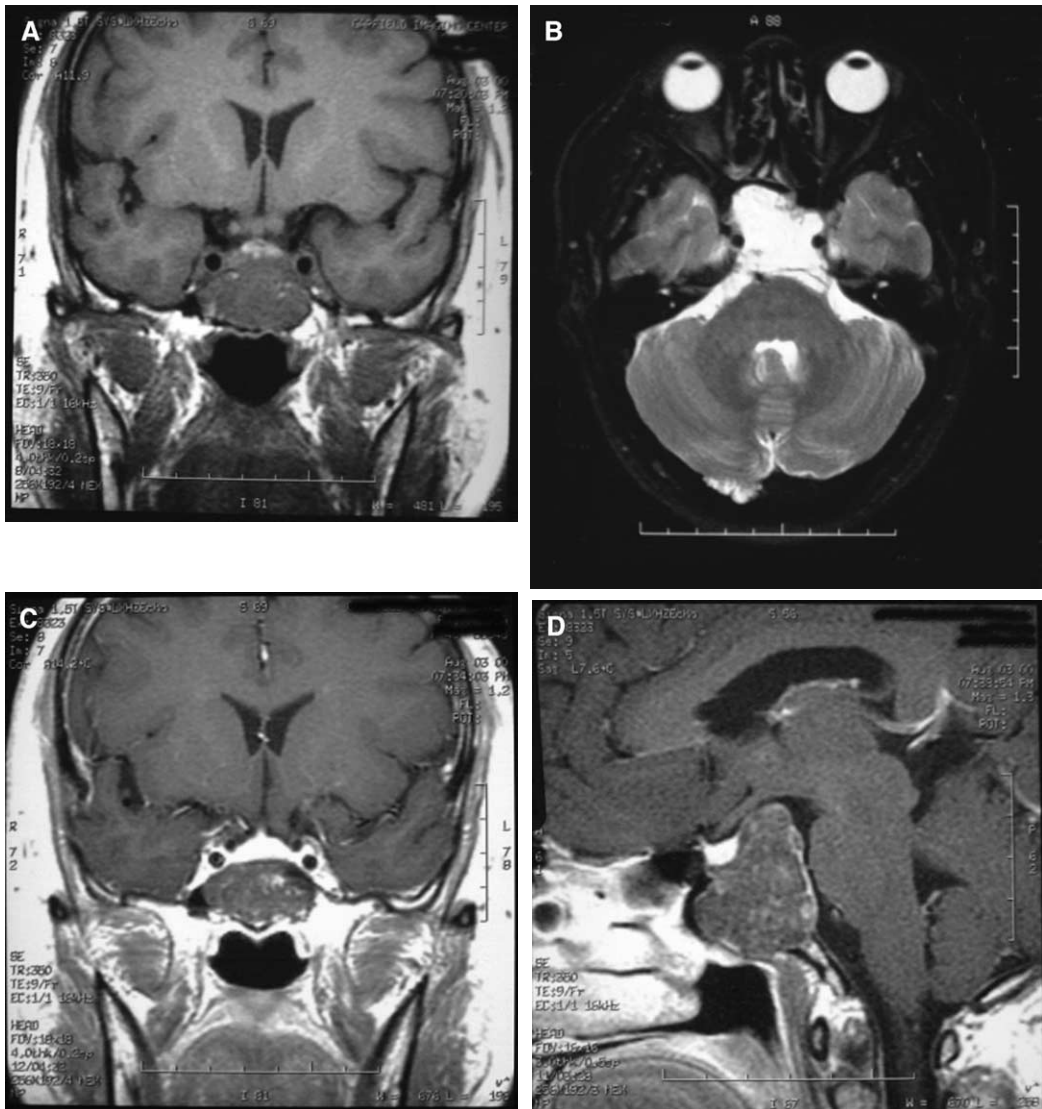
Chordoma of the clivus. (A) Coronal T1-weighted image shows a hypointense mass inferior to the pituitary gland and involving the sphenoid sinus and clivus. (B) Axial T2-weighted image shows the mass to be hyperintense. (C) Coronal postcontrast T1-weighted image demonstrates slight enhancement of the mass. Note the intense enhancement of the pituitary gland. (D) Sagittal postcontrast T1-weighted image shows slight enhancement of the mass with the markedly enhancing pituitary seen at its superior aspect.
